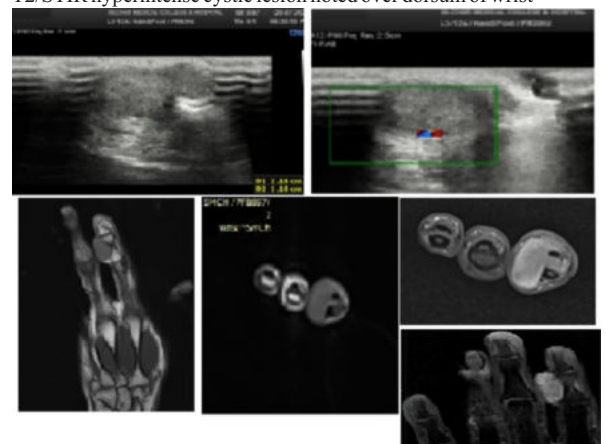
USG: A lobulated hypoechoic lesion of the size measuring approx. 1.9cm x 1.6cm noted arising from the tendon sheath of flexor digitorum profundus in the medial aspect of the right middle phalanx and showing minimal increased vascularity on color Doppler study.
